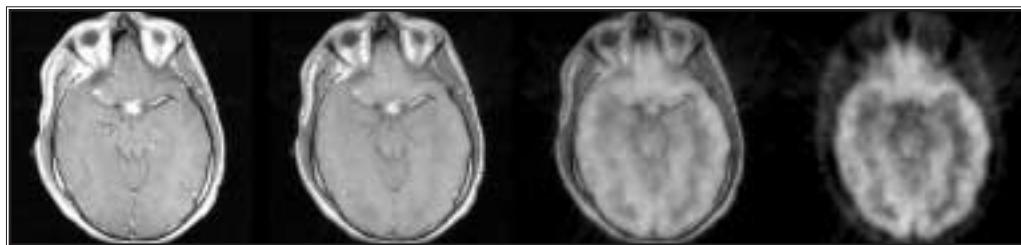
15-year-old boy with optic glioma. Registered images from left to right are 100% contrast-enhanced T1 MR; 67% MR, 33% PET; 33% MR, 67% PET; image on right is 100% PET. MR image demonstrates contrast-enhancing lesion arising from optic chiasm. FDG-PET image demonstrates minimal FDG (similar to white matter) in low-grade tumor.
